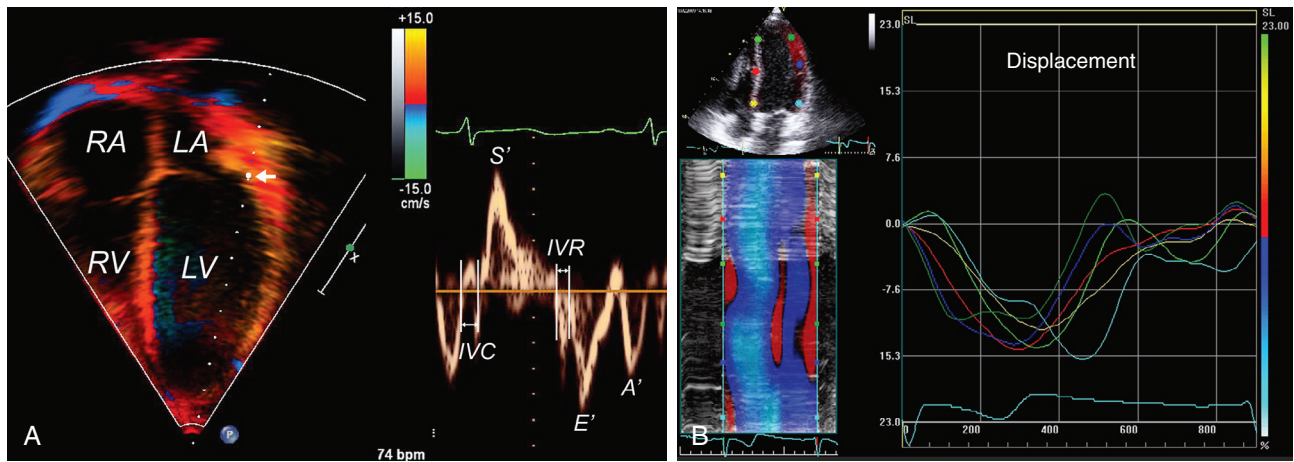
■ Evaluation of myocardial motion by echocardiography. A, Tissue Doppler imaging. Left ventricular myocardial velocity is sampled at the level of the mitral valve annulus (arrow). The velocity-time curve shown on the right panel demonstrates myocardial velocities relative to the apex. B, Speckle-tracking evaluation of left ventricular wall motion evaluated from the apical four-chamber view. Displacement of the left ventricular free wall and septum is simultaneously tracked in multiple points. A' , Late (atrial) diastolic velocity; *bpm*, beats per minute; E' , early diastolic velocity; *IVC*, isovolumic contraction period; *IVR*, isovolumic relaxation period; *LA*, left atrium; *LV*, left ventricle; *RA*, right atrium; *RV*, right ventricle; S' , systolic velocity.
